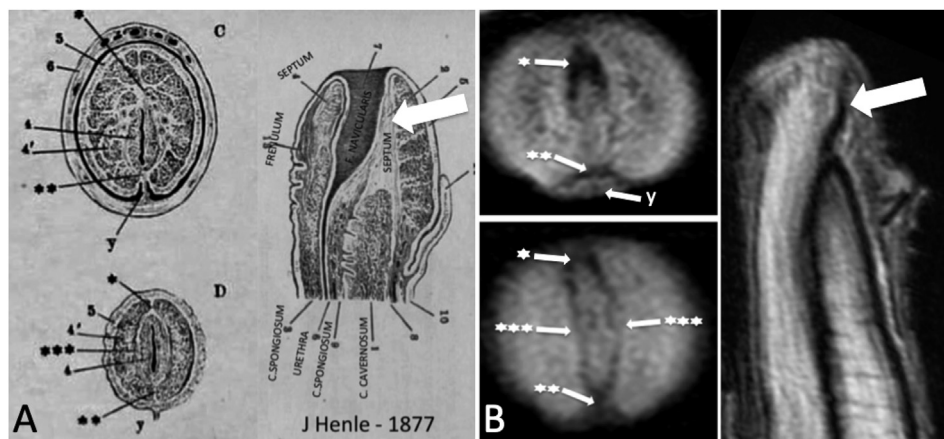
A) Dr Friedrich Gustav Jacob Henle's description of the median fibrous tissue surrounding the fossa navicularis as 'septum glandis' (*), its extensions as upper (*) and lower () median septum, and the frenulum (y). B) MR images of the penis show the same anatomical structures and the upper median septum, also known as the "distal ligament" or "corporo-glans ligament" (large arrow) [5].
